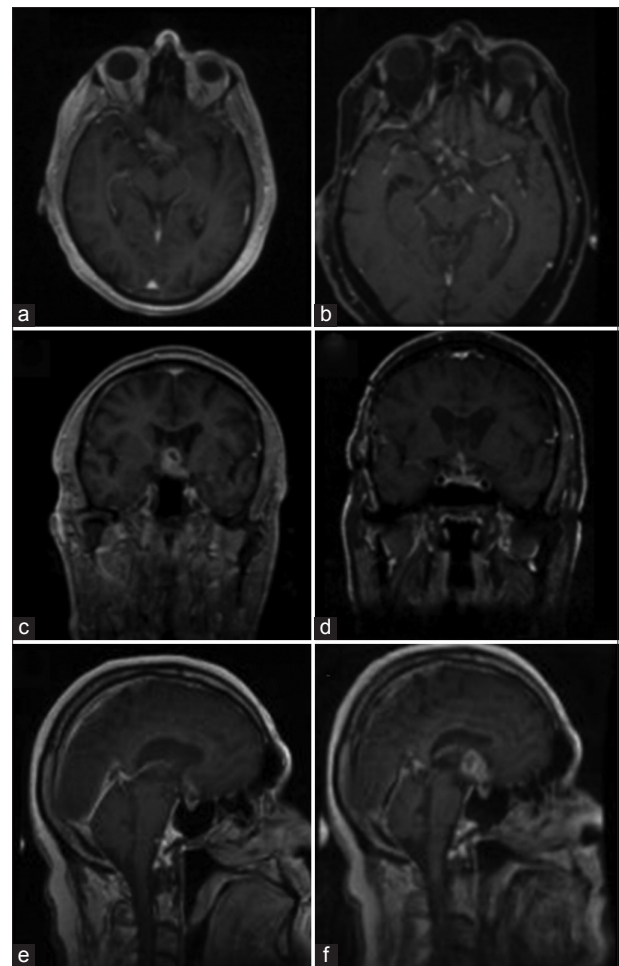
(Case 4) Magnetic resonance imaging axial T1 post-contrast, with no fat saturation (a) and with fat saturation (b) showing enhancement of the right prechiasmatic optic nerve with extension to the chiasm also in the left side. (c and d) Coronal T1 fat saturation post contrast showing progression of the findings with enhancing lesion extending from the chiasm to the floor of the 3rd ventricle (2 months later). (e and f) Sagittal section showing progression at the same time point
